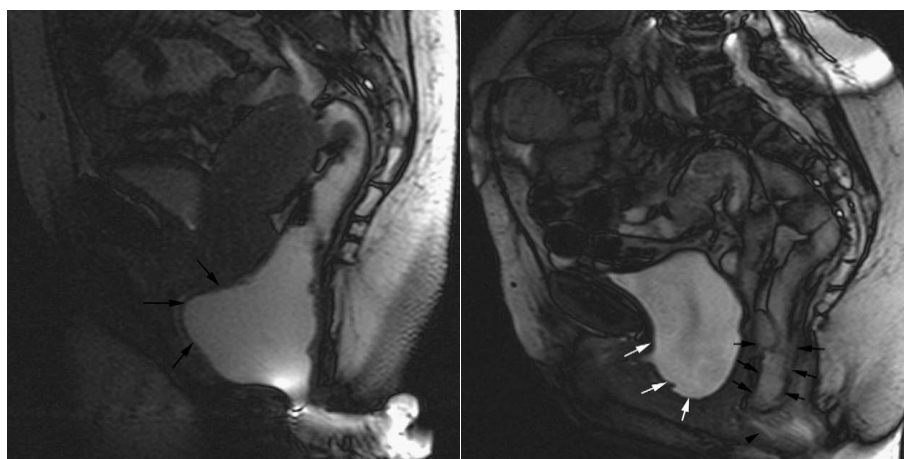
Sagittal FISP images though the midline of the pelvis in a female patient during MRI proctography. On the left image is shown a large rectocele (black arrows). On the right image is demonstrated a loop of a small bowel has descended anterior to the rectum to form a large enterocele (black arrows). Additionally, is noted a presence of cystocele (white arrows) and small collapsed rectocele (arrow head) [114].
